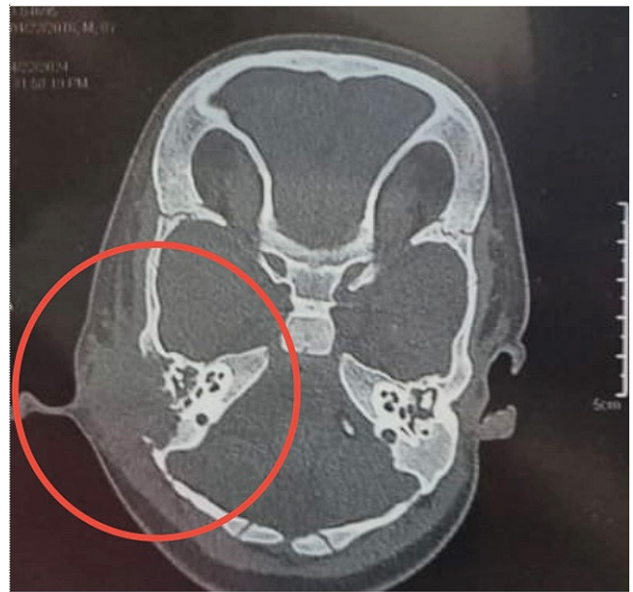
HRCT Temporal Bones - Soft tissue density in the right middle ear cavity causing erosion of the mastoid bone
